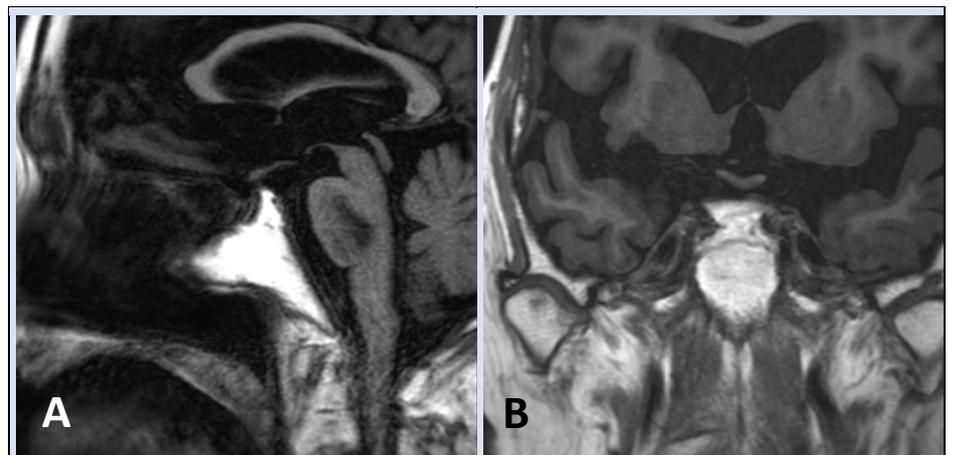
MRI T1-weighted image (sagittal and coronal planes) 8 weeks after chemotherapy.
